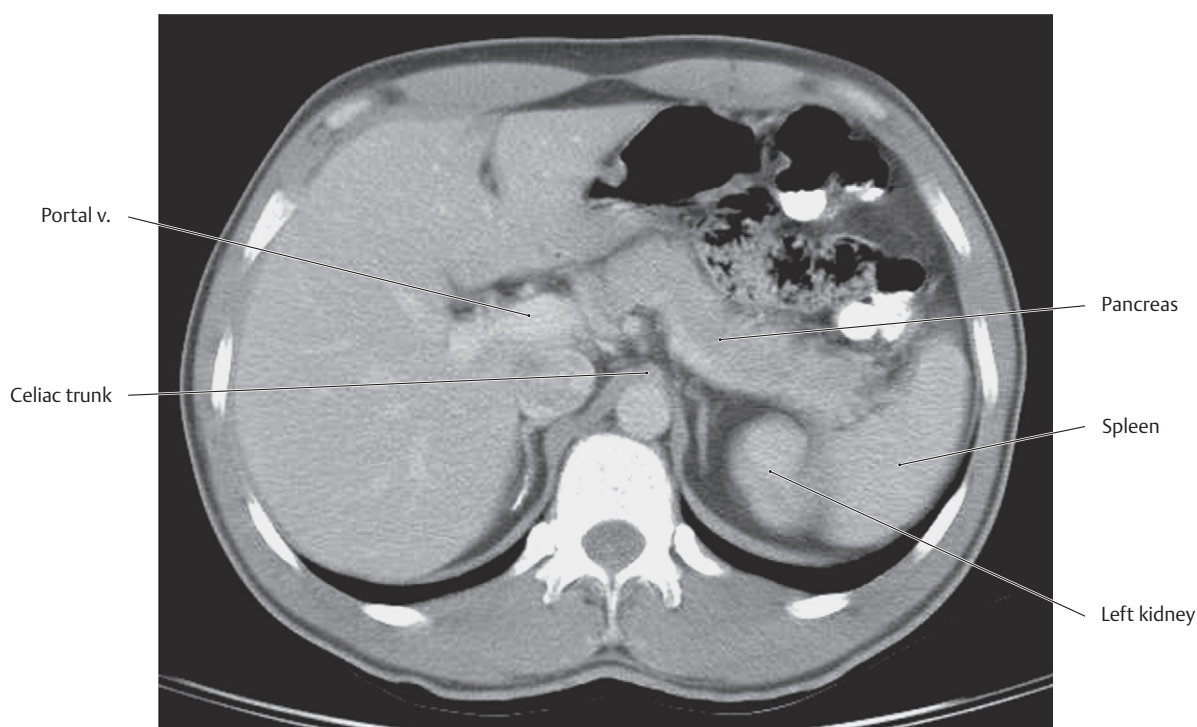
CT of the abdomen at the L1 vertebral level
